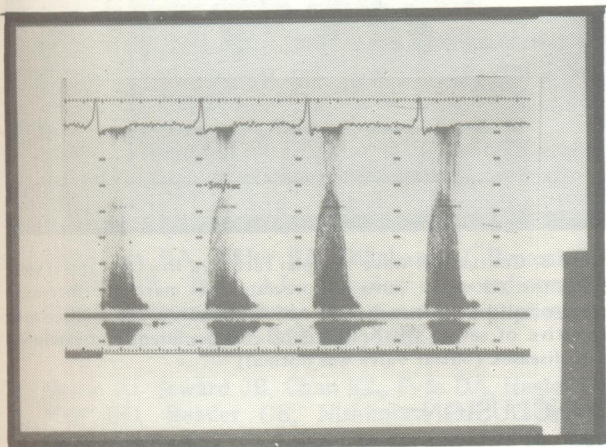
Continuous wave Doppler tracing in a patient with severe aortic stenosis recorded from the suprasternal view.
